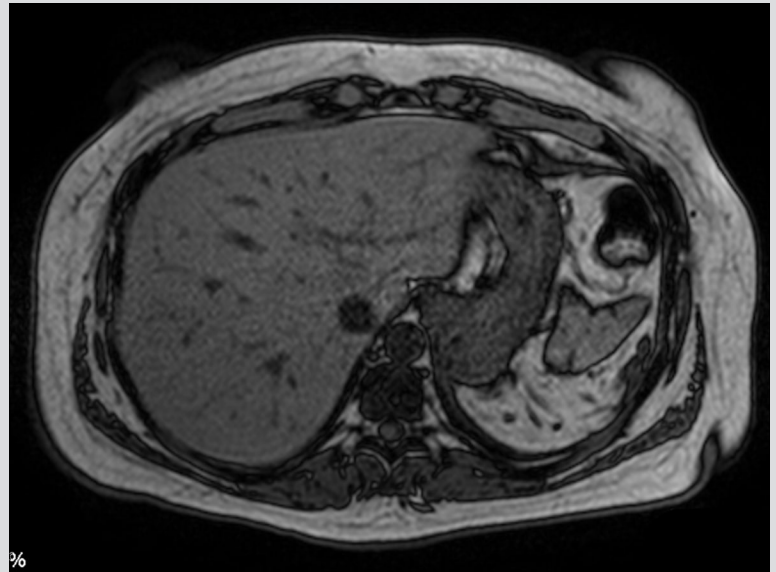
Cross-sectional MRI view of the upper abdomen
